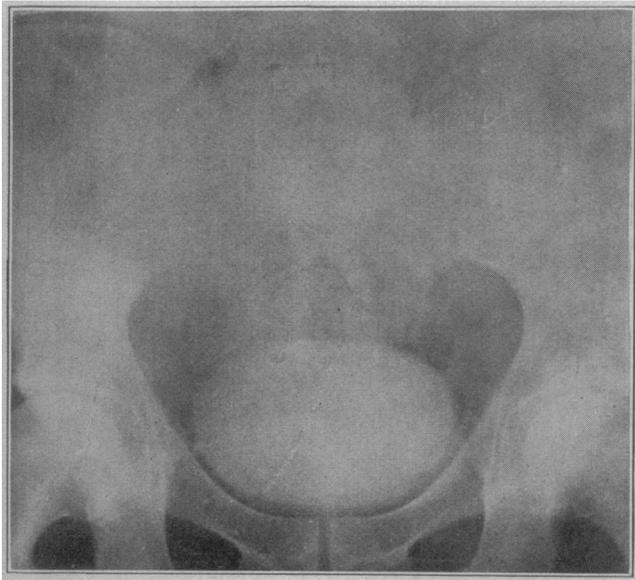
The patient received one dose of 5 gm. of sodium diiodid by mouth, and a roentgenogram was made three hours after the ingestion of the drug. A perfect outline of the full bladder was revealed.
